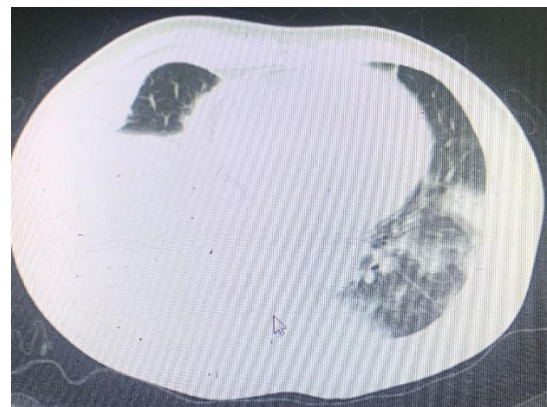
Axial CT thorax showing massive right-sided haemothorax and pulmonary compression.
